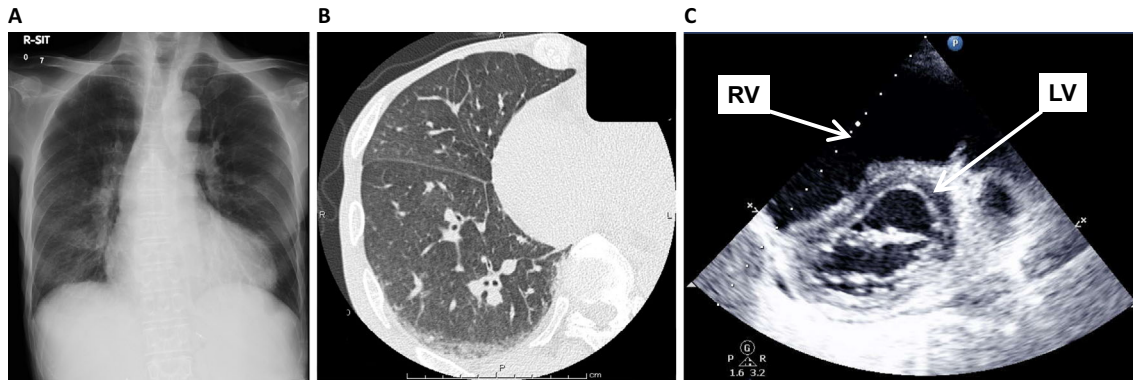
(A) Radiographic findings of chest X-ray. Chest X-ray showed cardiomegaly, the protrusion of the right second aortic arches, and ground-glass opacity, suggesting overburden of the right heart system. (B) Radiographic findings of chest computed tomography. Chest computed tomography indicated thickening of the interlobular septum, granular shadow, wall thickening of the bronchovascular bundle, and ground-glass opacity, findings that were characteristic of pulmonary veno-occlusive disease. (C) Findings of cardio-ultrasonography. The dilation of the right ventricle (RV) and compression of the left ventricle (LV) wall suggested overburden of the right heart system.
